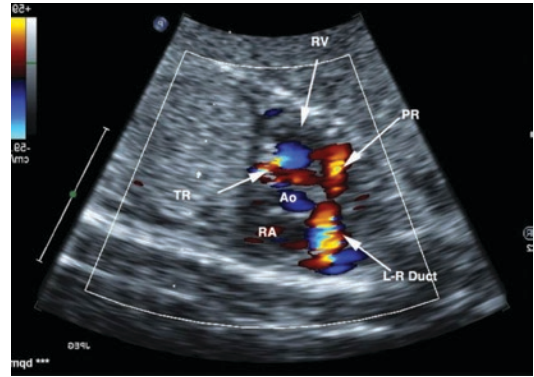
This fetal echocardiogram was taken from a fetus near term and shows features of the so-called circular shunt. This Doppler color flow superimposition on a cross-sectional image shows tricuspid regurgitation (TR). With ineffective forward flow from the right ventricle, pulmonary blood flow is derived from the ductus shunting left-to-right (L-R Duct). Because the pressure in the pulmonary artery is systemic and the pulmonary valve is not functioning well, there is pulmonary regurgitation (PR). Other abbreviations are (Ao) aorta (RA) right atrium
